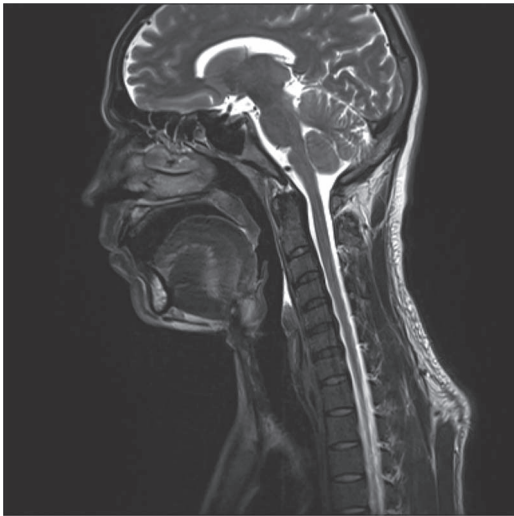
The Magnetic Resonance Imaging (MRI) of the cervical spine revealed no abnormalities in the T-2 weighted sagittal sequence.
